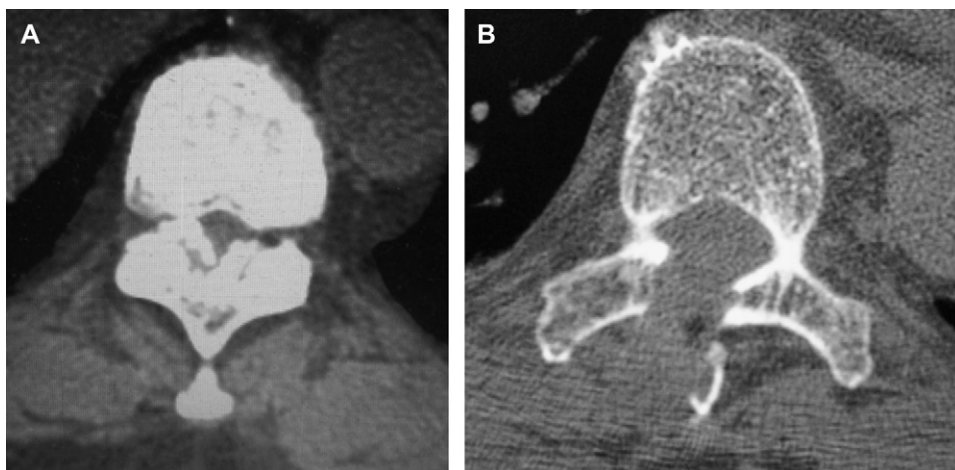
(A) Preoperative axial CT scan demonstrates the increased density of the ossification changes present in a patient who has thoracic OLF. (B) Postoperative axial CT scan after minimally invasive laminectomy and removal of OLF demonstrates adequate surgical decompression of ossified ligamentum with restoration of normal spinal canal caliber.
